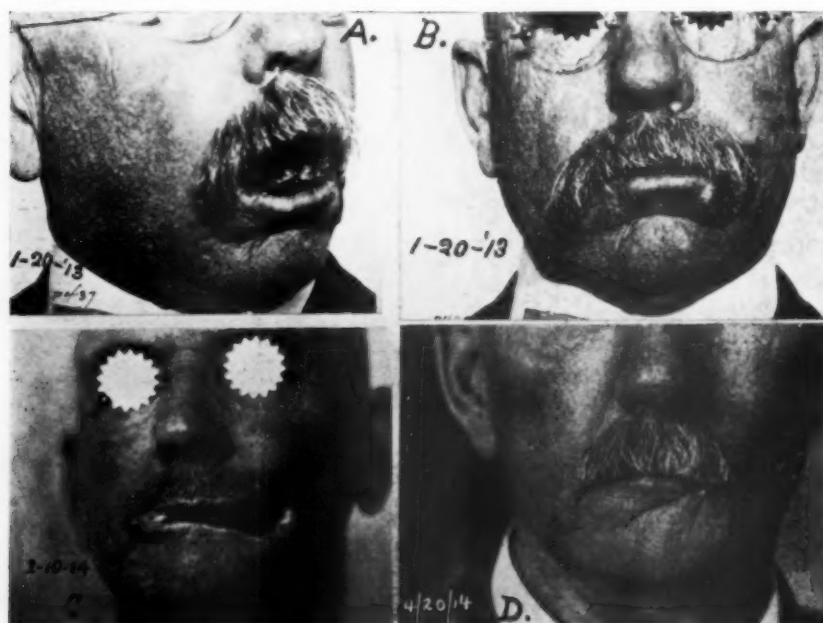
(a) and (b)—Drs. Deemer and Dachtler's patient. Duration twelve years. Had been treated previously by the x-rays. Epithelioma involved two-thirds of the lower lip, one-third of the upper lip, the inside of the cheek to the angle of the jaw. No palpable lymph nodes, probably because of the previous radiation treatment. Destroyed by electro-coagulation January 20, 1913 with application of radium inside the mouth and x-ray treatment over the wound and submaxillary region.
